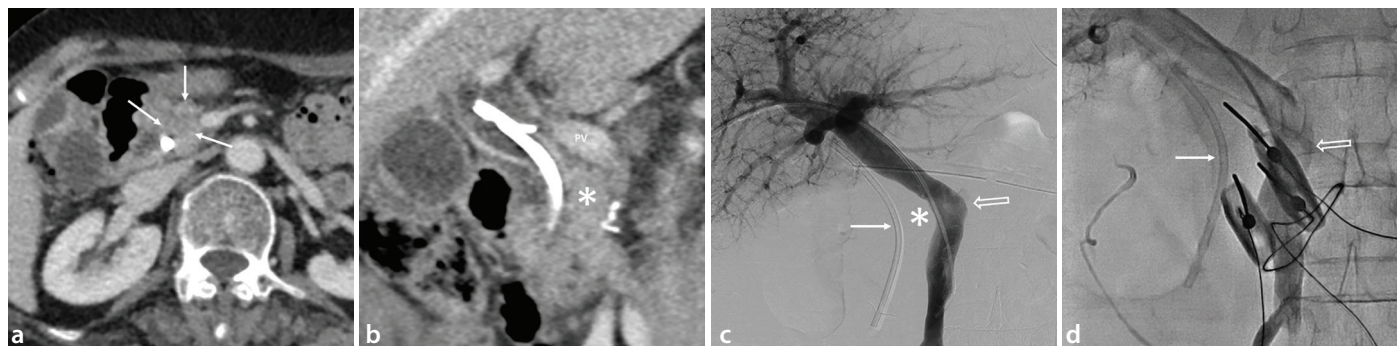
Portotocholedochal interval. An 82-year-old woman with locally advanced pancreatic cancer. (a) Contrast-enhanced computed tomography (CT) shows a 2.0-cm mass in the pancreatic head. (b) Coronal CT depicts the portotocholedochal interval (*), defined as the anatomical interval between the common bile duct (represented by a plastic biliary stent) and the portal vein (PV). (c) Direct portography further delineates the portotocholedochal interval (*) between the plastic stent (arrow) and PV (open arrow). (d) A double clustered electrode configuration with an additional single electrode was inserted under fluoroscopic guidance. The plastic biliary stent (arrow) and contrast opacification of the PV (open arrow) are visible.
